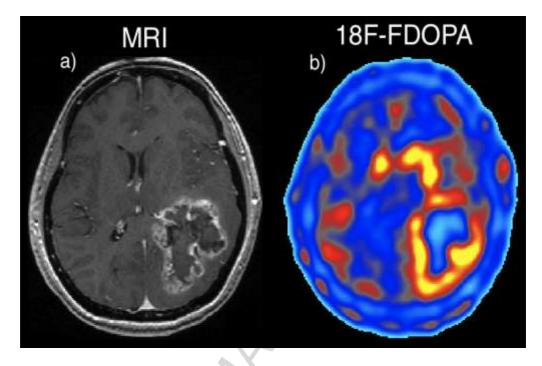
a) Contrast enhanced MRI and b)₁₈F-FDOPA imaging of a primary high-grade glioma (grade IV – GBM).
